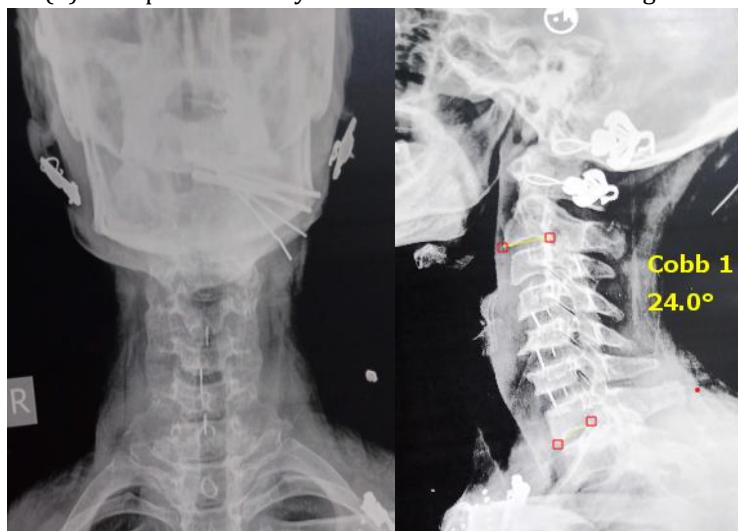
Postoperative X-ray AP and lateral view at 1 month with Cobb angle 24° .
